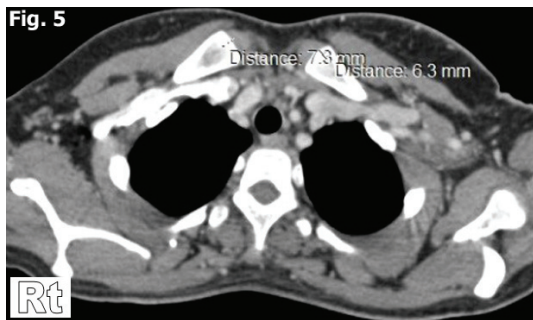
A computed tomography photo (coronal section) showing how to measure the height of medullary canal of both clavicles.
